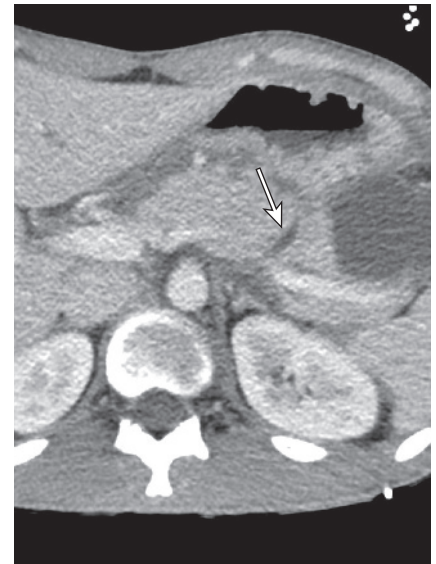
Axial post-contrast computed tomography of the abdomen demonstrating a laceration of the pancreas (arrow).
